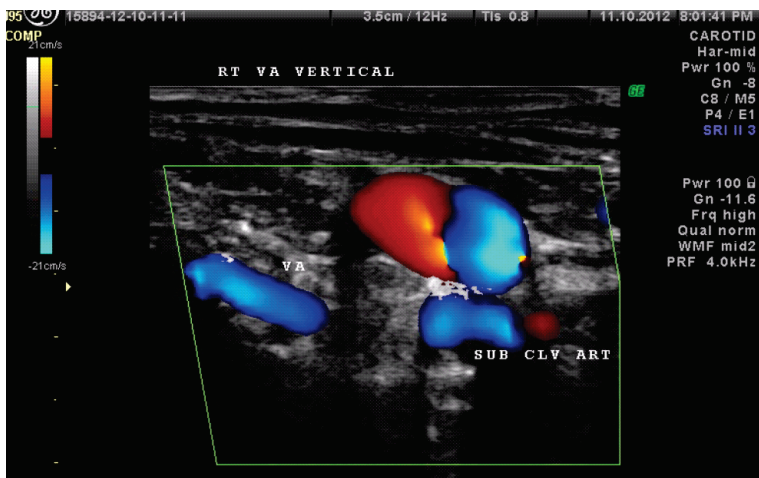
The above colour Doppler image showing reversal of flow in the vertebral artery. Note the colour difference between CCA & vertebral artery indicating different directions.
